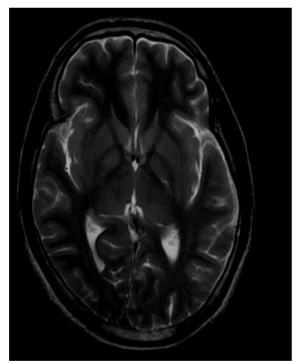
MRI scan case 1 (Bilateral symmetrical hyperintensity in Globus pallidus)
